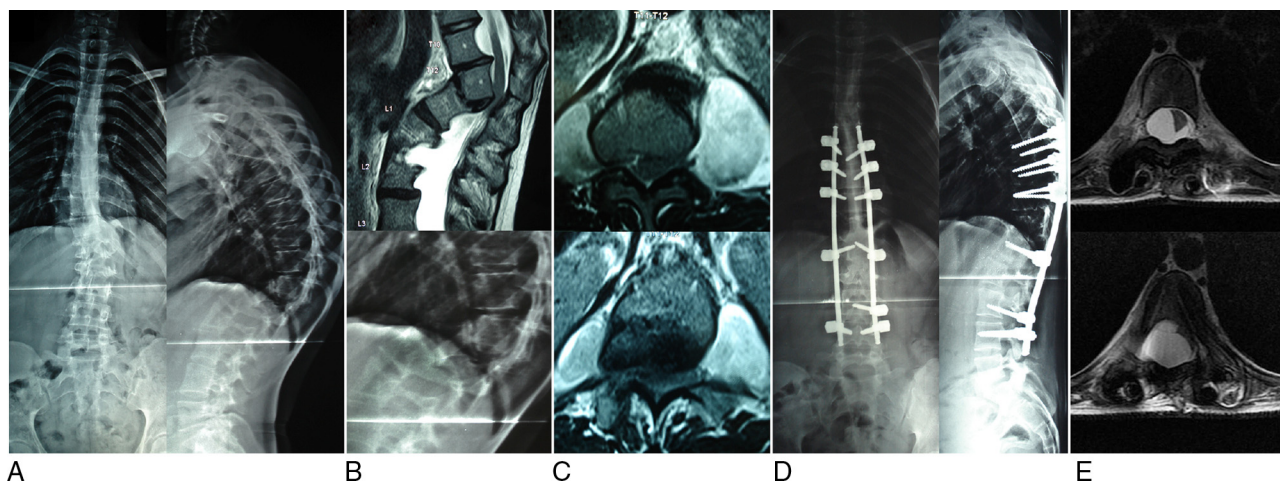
Kyphoscoliosis due to dysplastic neurofibromatosis, with 90-degree rotation of T11 on T12, with spinal compression. Patient presented only lower limb hyperreflexia, but was bedridden due to pain. (A) Panoramic radiograph. (B) Magnetic resonance imaging and radiograph, focused showing the angular deformity with 90° of T10–T12 kyphosis and spinal compression. (C) Magnetic resonance imaging showing the extent of the meningeoceles around the angular deformity that led to the transdural approach. (D) Postoperative radiograph showing good correction of the deformity. (E) Magnetic resonance imaging seven months after the initial surgery showing an arachnoid cyst at the upper end of the instrumentation, two levels above the VCR, with important compression and displacement of the spinal cord. The patient had rapidly progressive spastic paraparesis, which persisted even after cyst surgery (case 9).
